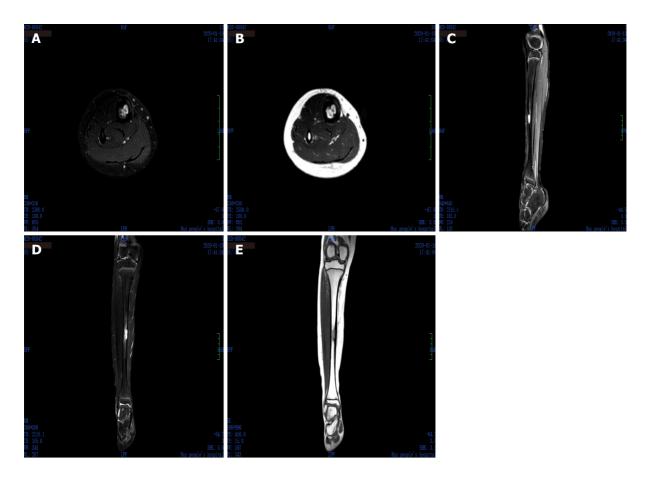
Magnetic resonance images of the tibia. Magnetic resonance images showing a sharply defined unclear lesion and high heterogeneous signal intensity on T1-weighted images and T2-weighted images.
